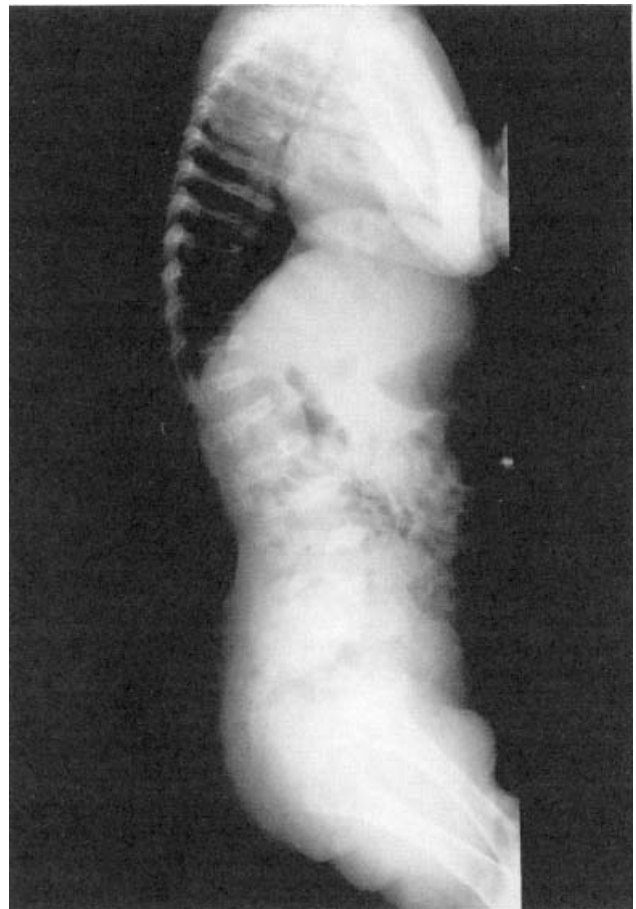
Radiograph of a newborn with dominant metatropic-like spondylo-epi-metaphyseal dysplasia showing marked platyspondyly.
